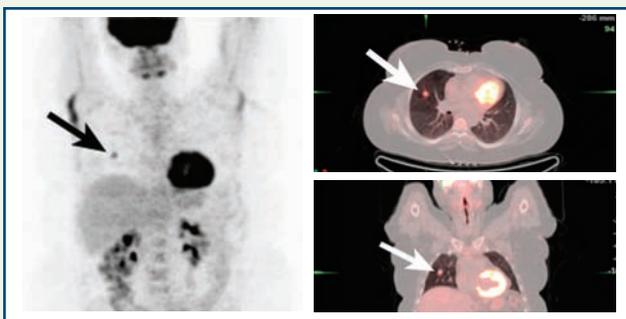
PET/CT June 26, 2009, demonstrating intense FDG uptake at SPN
